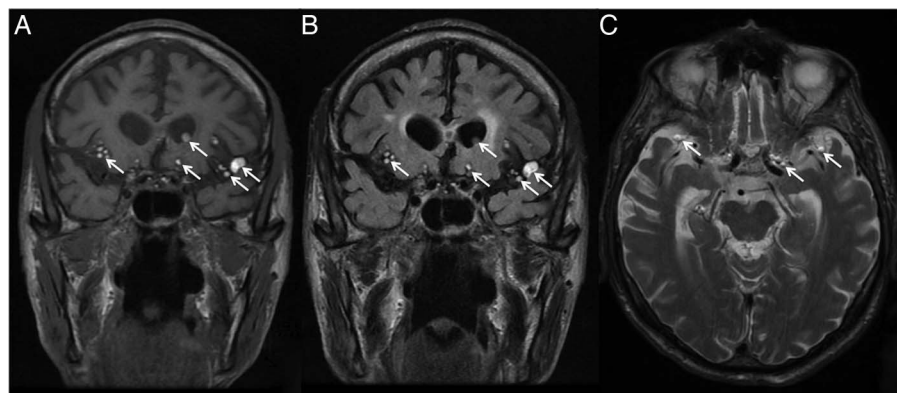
(A) Coronal MRI (T1 sequence) showing hyperintense signals (arrowed) in the parasellar region, sylvian fissures and left lateral ventricle. (B) Coronal T2 fluid-attenuated inversion recovery image showing hyperintense signals (arrowed) in a distribution corresponding to the T1 image along with bilateral periventricular areas of high signal best explained by small vessel disease. (C) Axial T2 image showing hyperintense signal (arrowed) in the parasellar region and anterior temporal lobes. These findings are consistent with extra-axial fat droplets.
